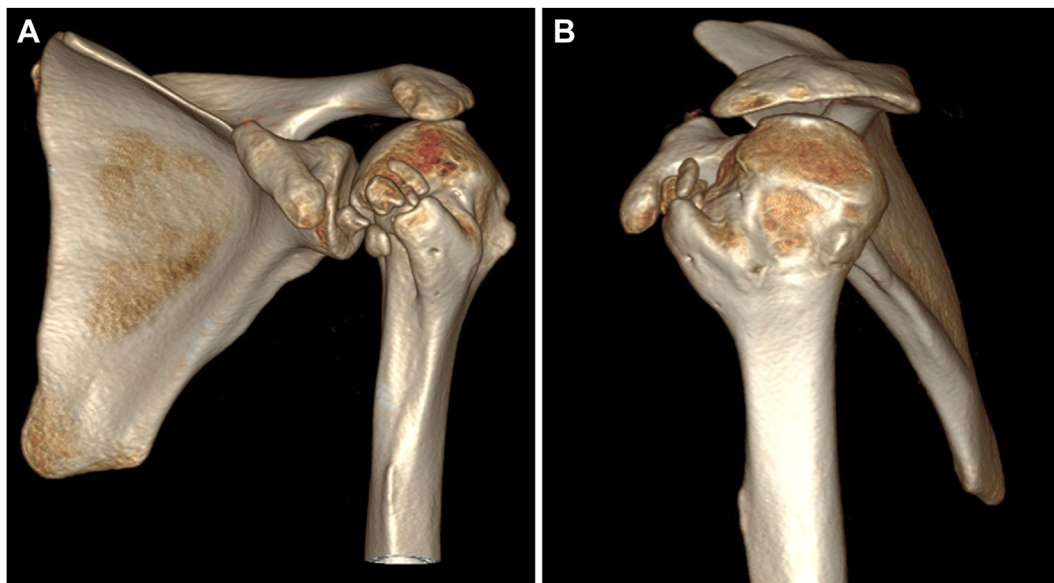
Preoperative computed tomography three-dimensional reformat of the left shoulder. (A) Anterior view showing the fragmented malunion of the greater tuberosity anterior to the lesser tuberosity. (B) Lateral view showing the extent of the greater tuberosity malunion, almost abutting against the coracoid process.
